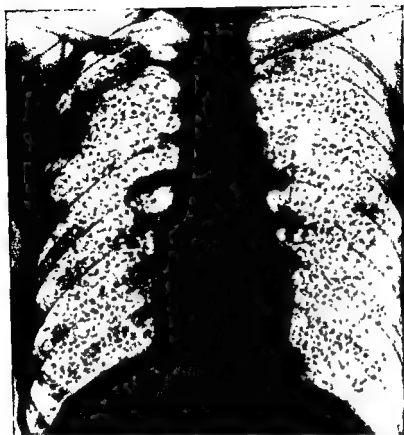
Silicotic nodulation. X-ray and section through part of the lung of a flint worker
